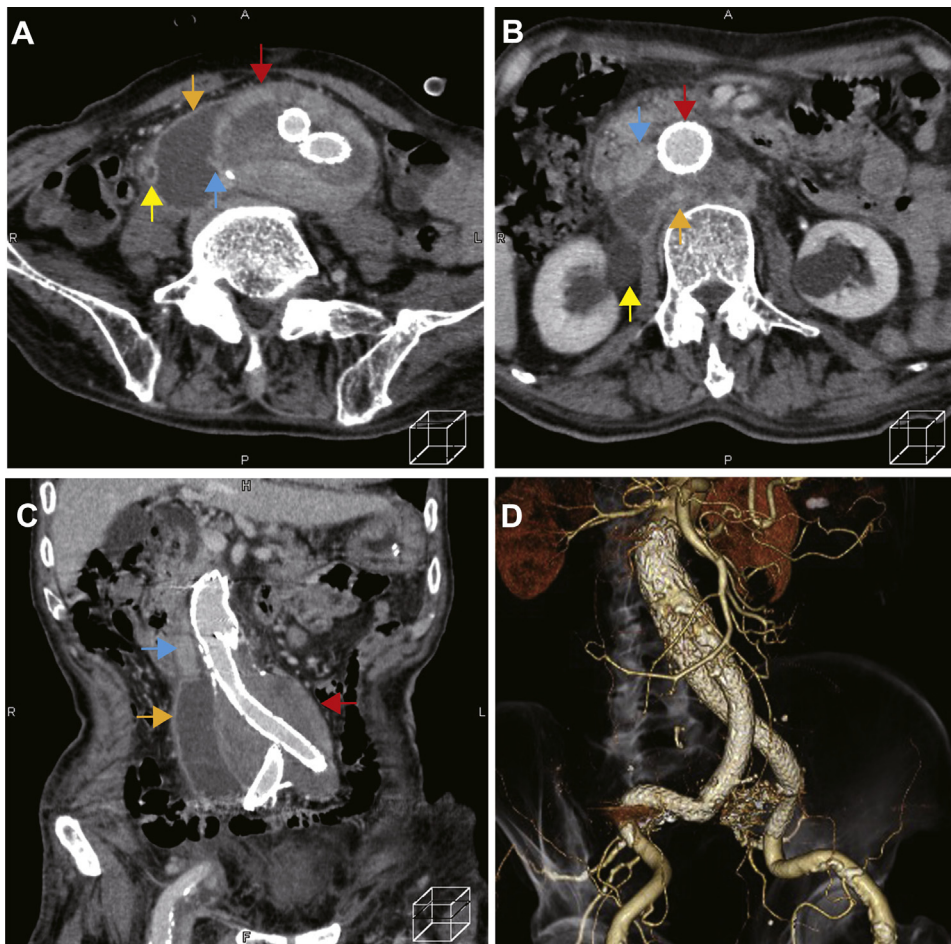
A and B, Delayed enhanced computed tomography (CT) axial images at L4 and L2. C, Coronal view of delayed enhanced CT. D, Three-dimensional CT image after stent graft placement. There was no evidence of endoleak. The red, orange, yellow, and blue arrows indicate the abdominal aortic aneurysm (AAA), periaortic lesion, right urinary tract, and inferior vena cava, respectively.
